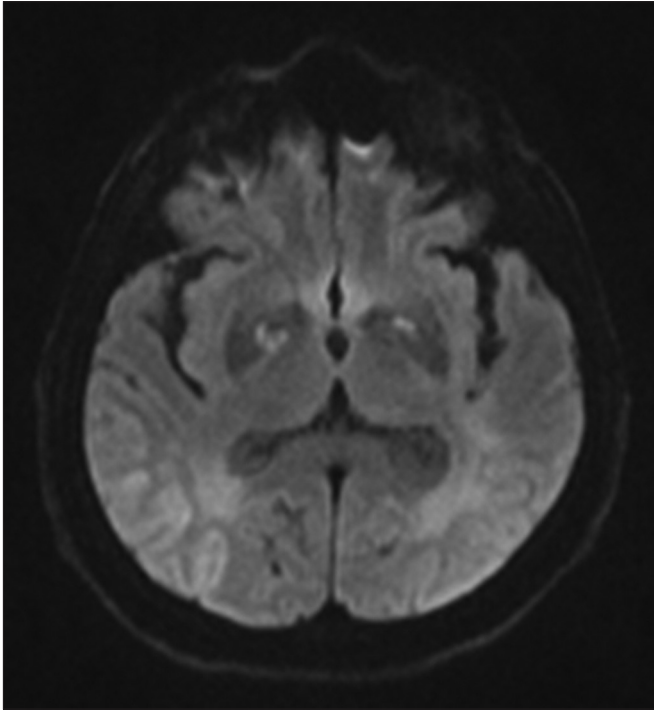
A 65-year-old woman with hypoxic-ischaemic encephalopathy due to cardiac arrest. DW MR image shows restricted diffusion in both the globi pallidi and occipital cortices.
